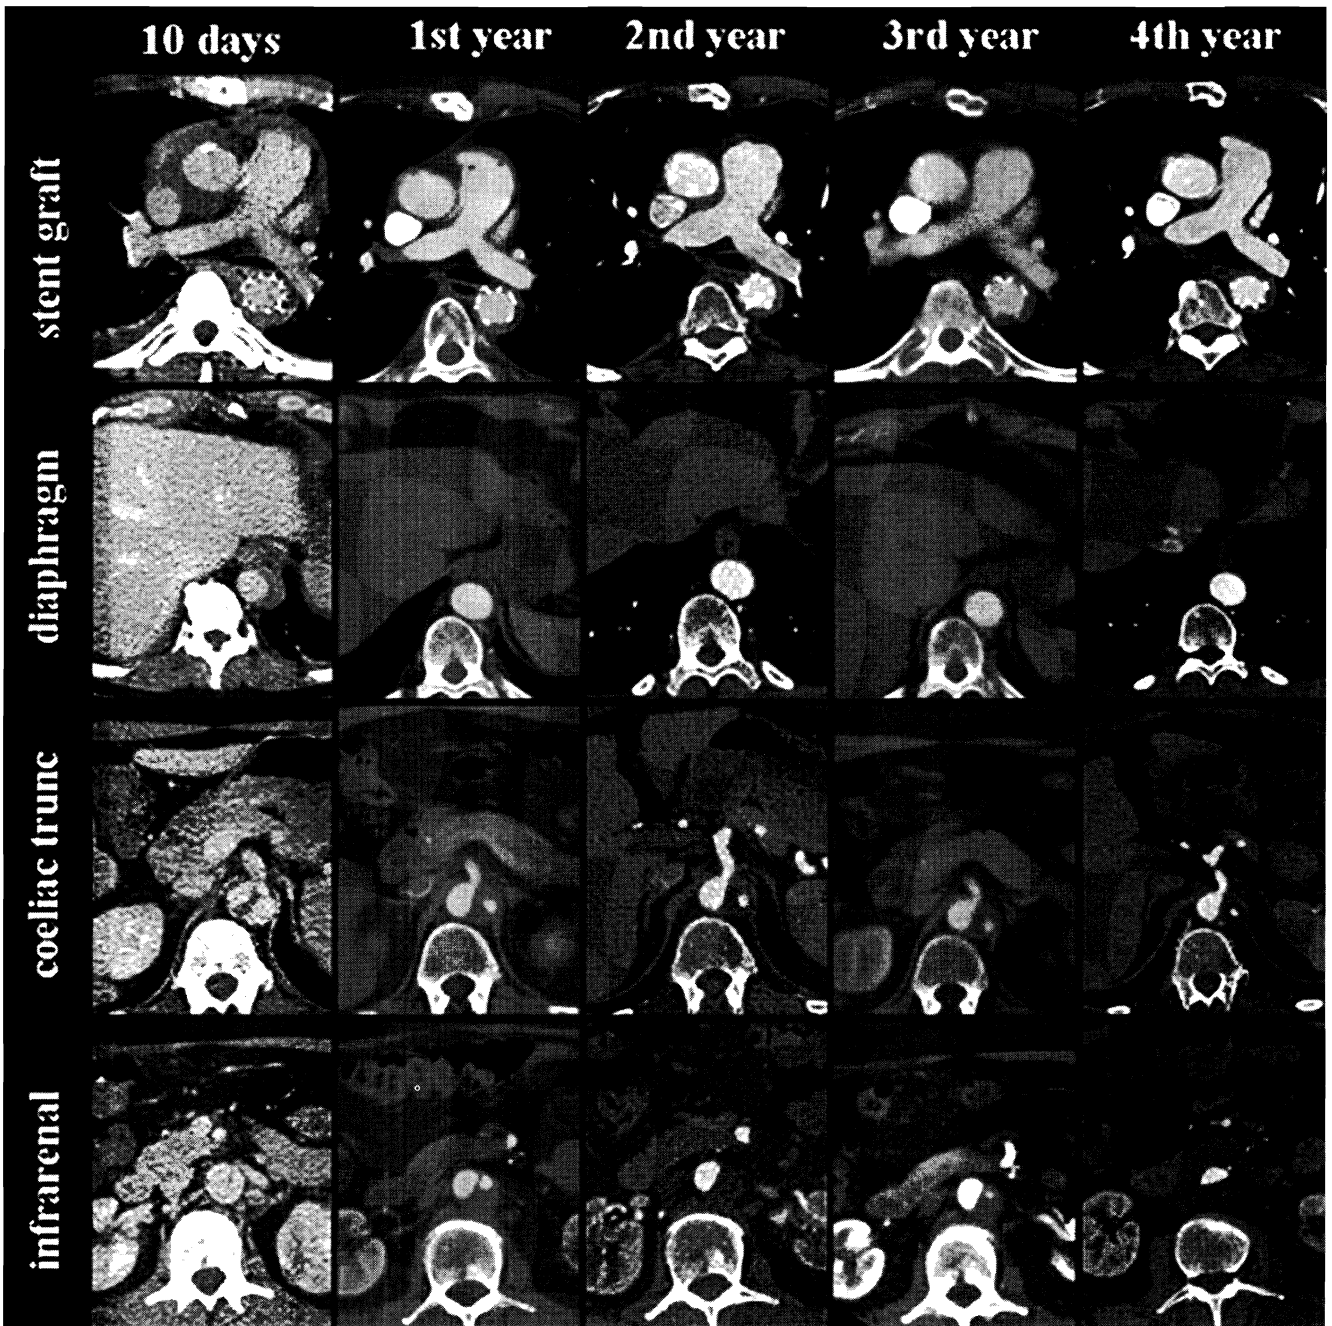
Case computed tomography study of a 52-year-old male with acute type I AD: durable thrombosis and shrinkage of the false lumen is documented at stent-graft and diaphragmatic level, while the true lumen and the partially thrombotic false lumen in the abdominal aorta remains stable over a period of four years.
